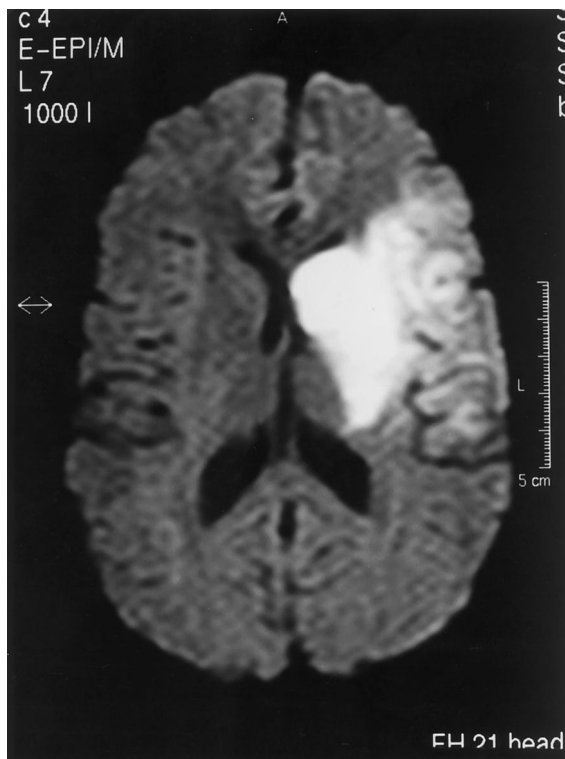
Axial diffusion-weighted MRI of the brain performed on the day of admission. Diffusion-weighted imaging showed fresh infarction of the left basal ganglia, left insula, and parietal lobe cortex.
